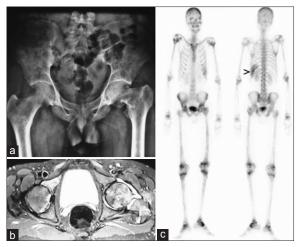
A 24-year-old man presented with pain in the hip. His hemoglobin was 8 g per deciliter, hemoglobin electrophoresis result: Hemoglobin (Hb) Ao 49% (reference range 80-99%), Hb A 2 2.9% (reference range <2-3.5%), Hb F 0.5% (<2.5%), Hb S 41.9% (<0.9%), Hb D nil, Hb C nil. Plain radiograph; (a) Revealed osteolytic lesion in the superolateral quadrant of head of left femur.(b) Magnetic resonance imaging revealed osteonecrosis in the head of left femur. Bone scan; (c) Showed increased inhomogeneous tracer distribution in the shaft of long bones bilaterally, pelvis bilaterally suggesting cortical infarcts. The head of left femur shows cold area with increased inhomogeneous uptake within, that is compatible with osteonecrosis. There is soft tissue tracer localization in the spleen (>) typical of Sickle cell anaemia
